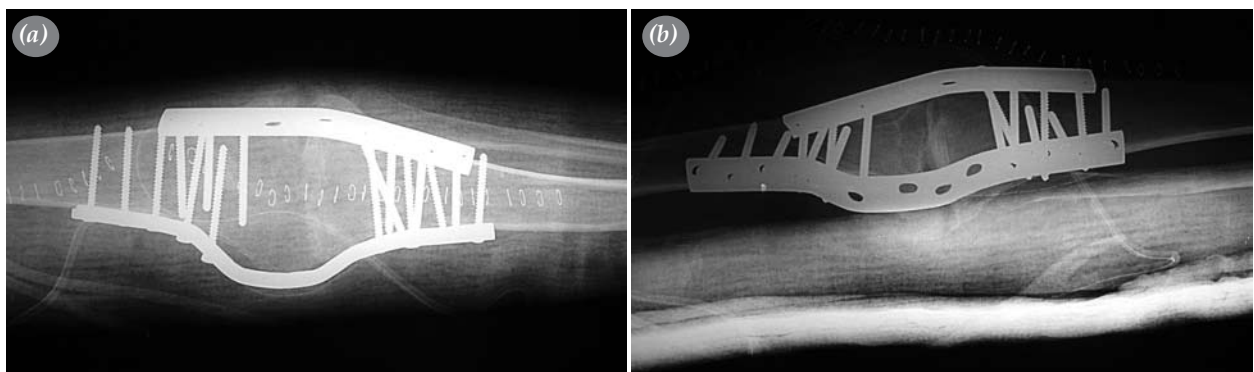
Postoperatively (a) Anteroposterior and (b) Lateral plain radiographs.
